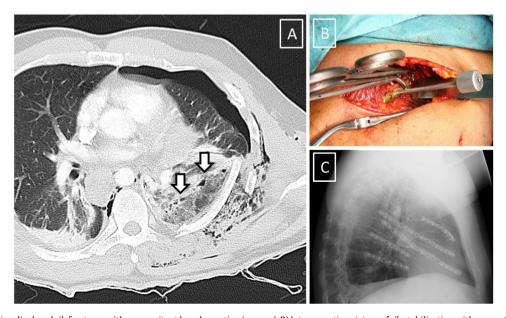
A) CT-scan showing displaced rib fractures with concomitant lung laceration (arrows). B) Intraoperative picture of rib stabilization with precontoured locking plates. C) Lateral chest x-ray showing the postoperative result after surgical stabilization of flail chest.
